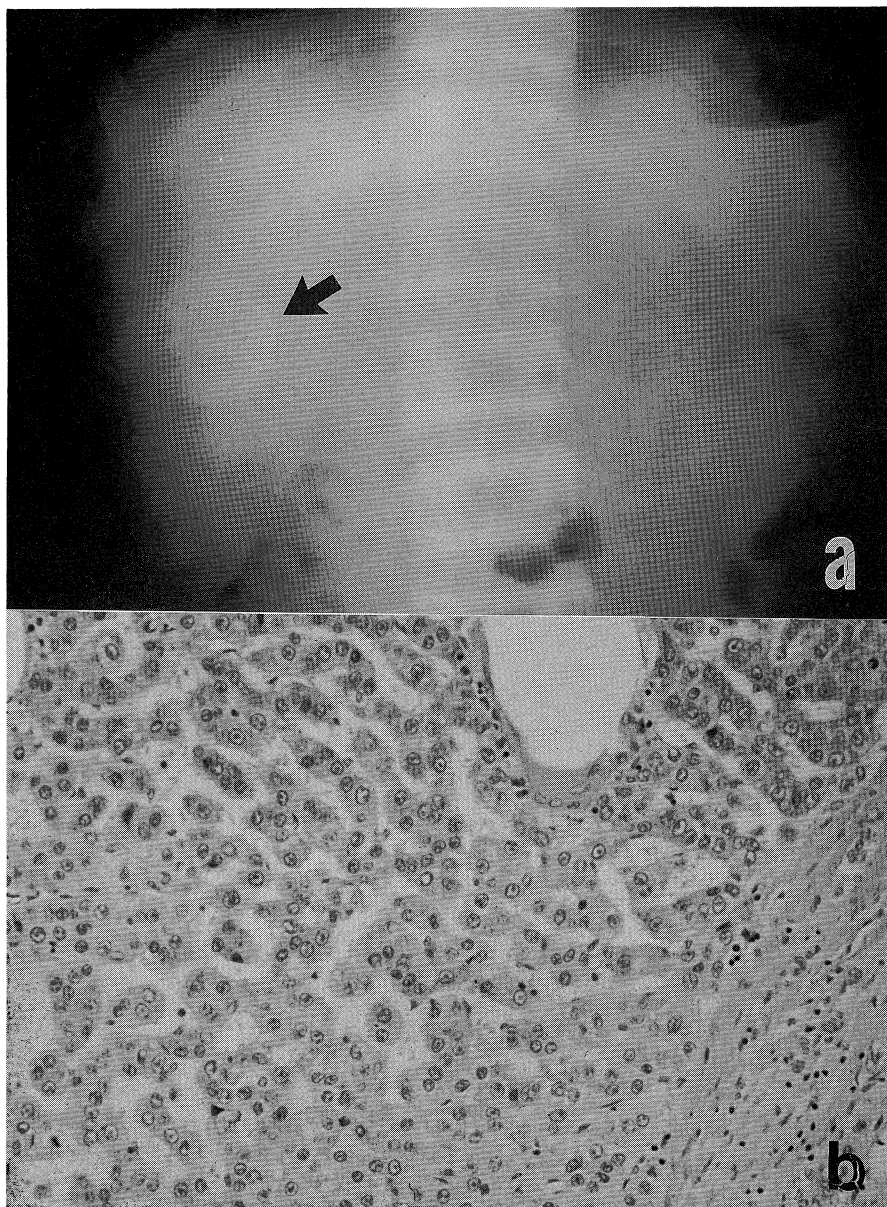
a. An abdominal radiograph demonstrates accumulation of Lipiodol (arrow) within the tumor (case 1).
